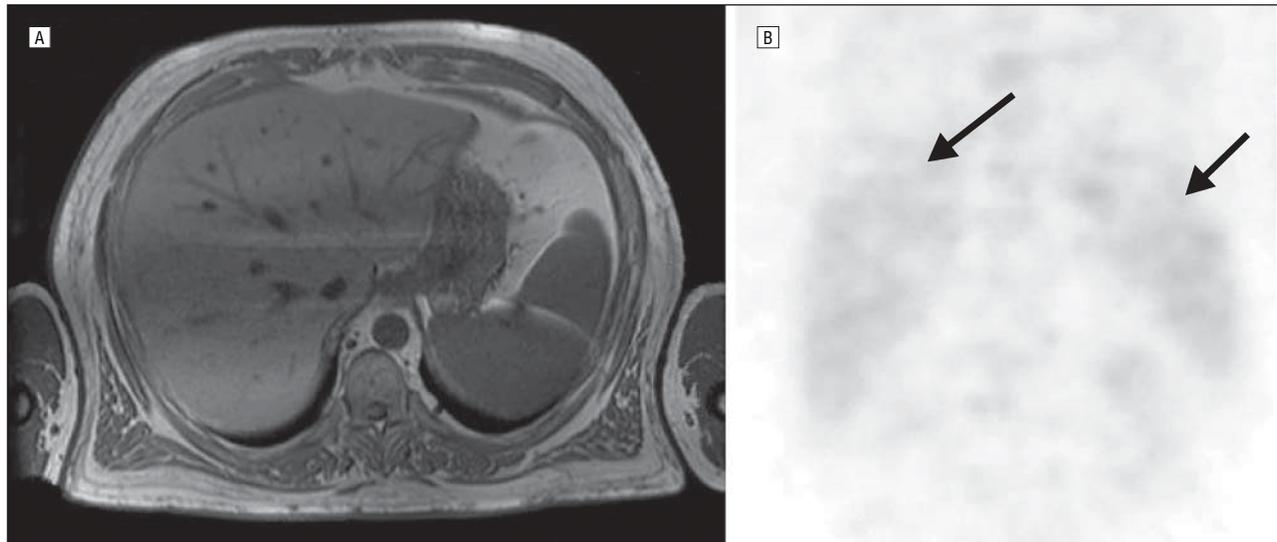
Magnetic resonance imaging scan (A) and positron emission tomographic (PET) scan (B) show a hepatosplenomegaly prior to treatment with imatinib. The PET scan reveals a homogeneous tracer accumulation in the liver and spleen (arrows).
